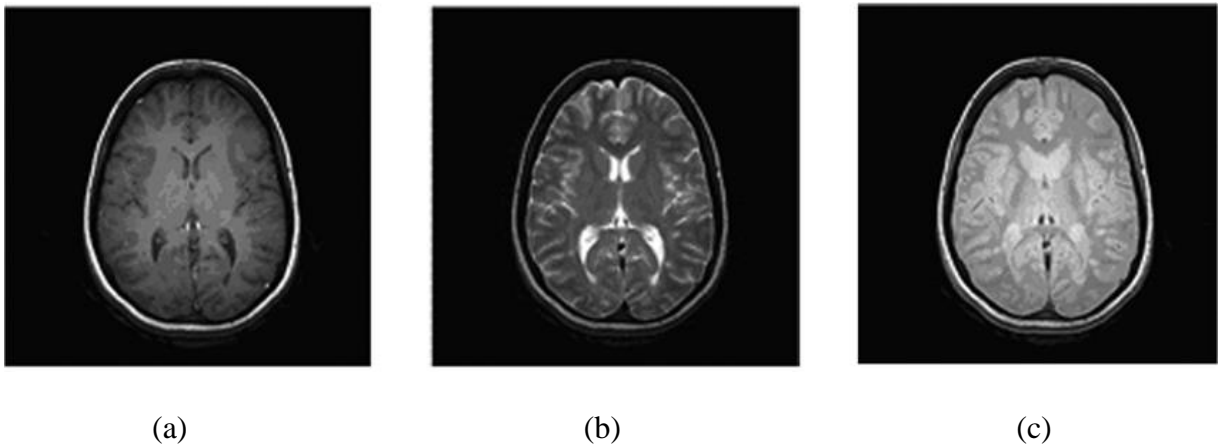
Representation of various MRI brain image contrasts:
